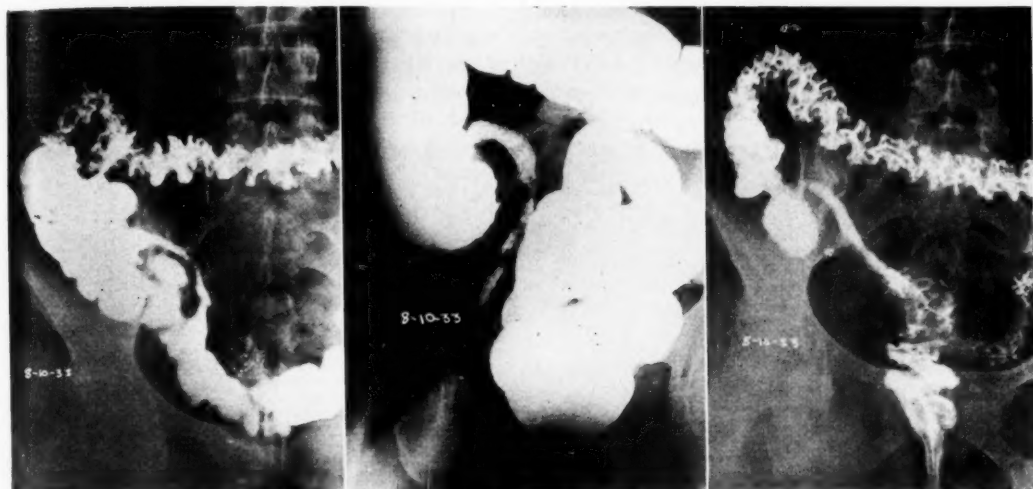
Diffuse ileitis in which only the terminal segments of the ileum are involved. The opaque meal (left) six hours after ingestion, showing the narrowing of the involved ileum. The colon and terminal ileum of the same patient are shown distended with the opaque enema (center) and after evacuation of the opaque enema (right). The roentgenologic findings of this disease described in the text are best elicited by this method.
